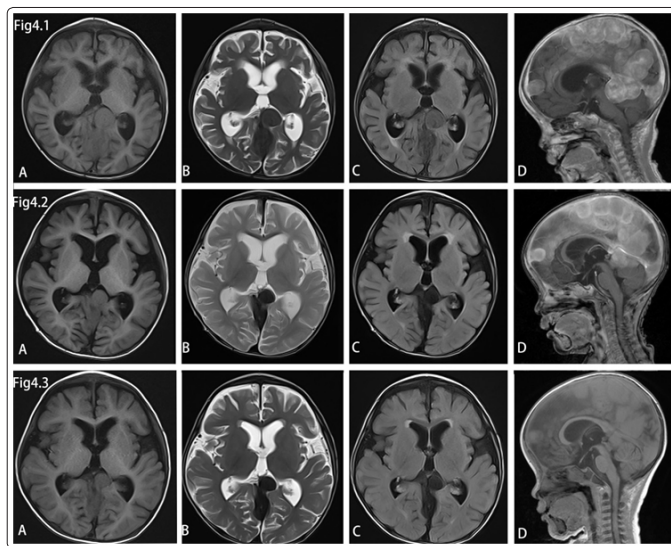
superior A-D: Axial T1 (A) showed that the lesions were little bit smaller than before. T2 weighted (B) and Axial (C) fluid attenuation inversion recovery (FLAIR) T1 weighted MR image show that signal intensity of lesion was little bit lower than before. Sagittal (D) T1 post gadolinium enhanced image shows reduced range of lesion than before.
